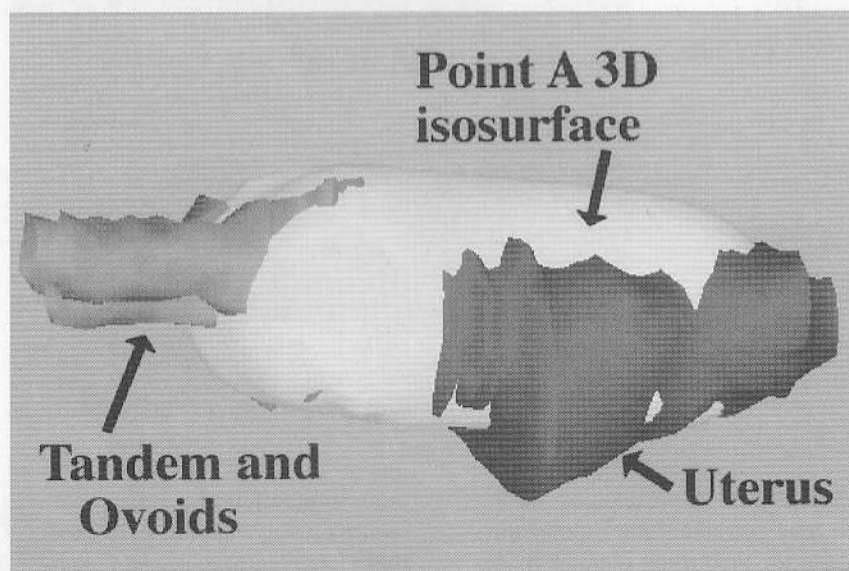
Reconstructed objects from CT scans demonstrate the isosurface solid object coverage of the uterus. The ovoids are partially enclosed by the dose (56 cGy/h) isosurface.
